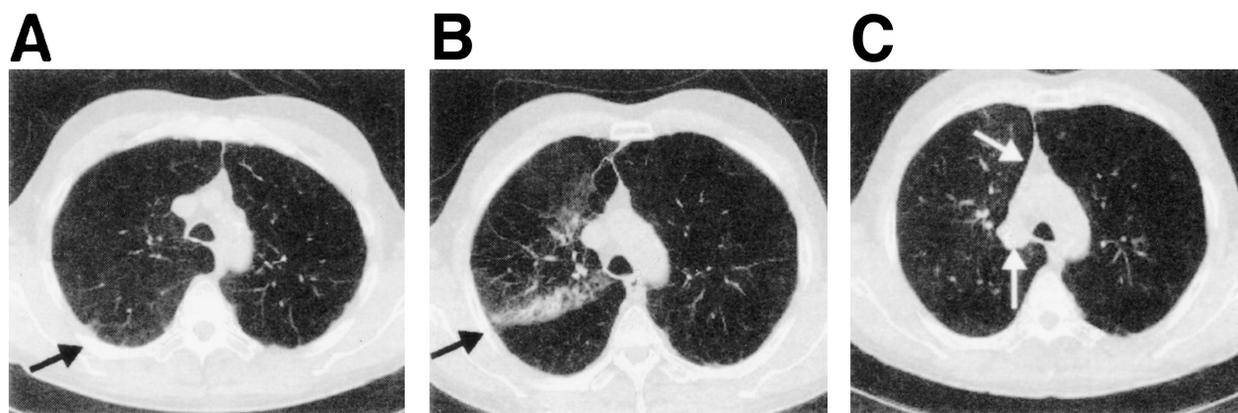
Computed tomograms of a patient who underwent bronchoscopic lung-volume-reduction surgery to the right upper lobe. A: Before surgery. B: One week after surgery. C: Four weeks after surgery. Black arrows point to major fissure. White arrows point to areas of collapse and volume reduction. (From Reference 41, with permission.)
